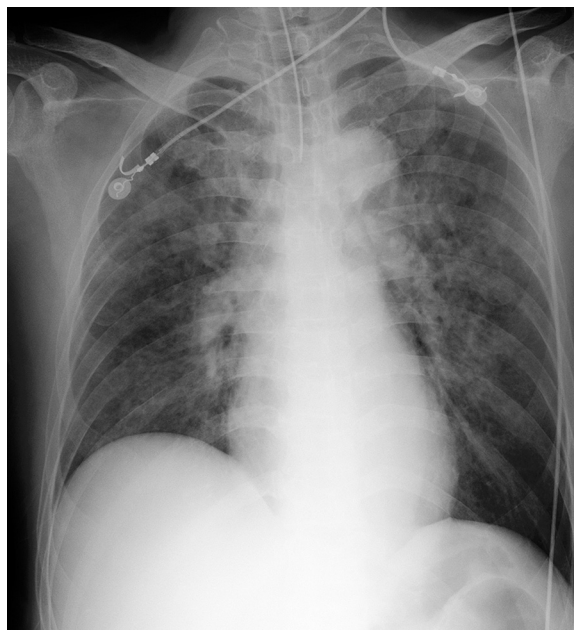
Chest X-ray shows diffuse pulmonary infiltrates in the lung indicating the presence of pulmonary edema.
